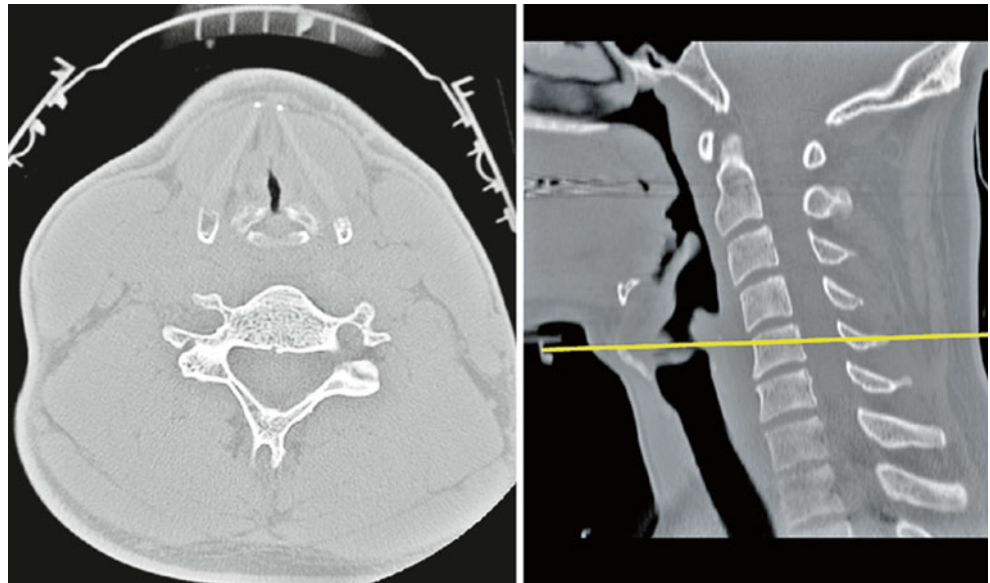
Cervical CT and MRI. These images are relatively unremarkable studies from the same subject, comparing the appearance of the same structure on both CT and T2 MRI
